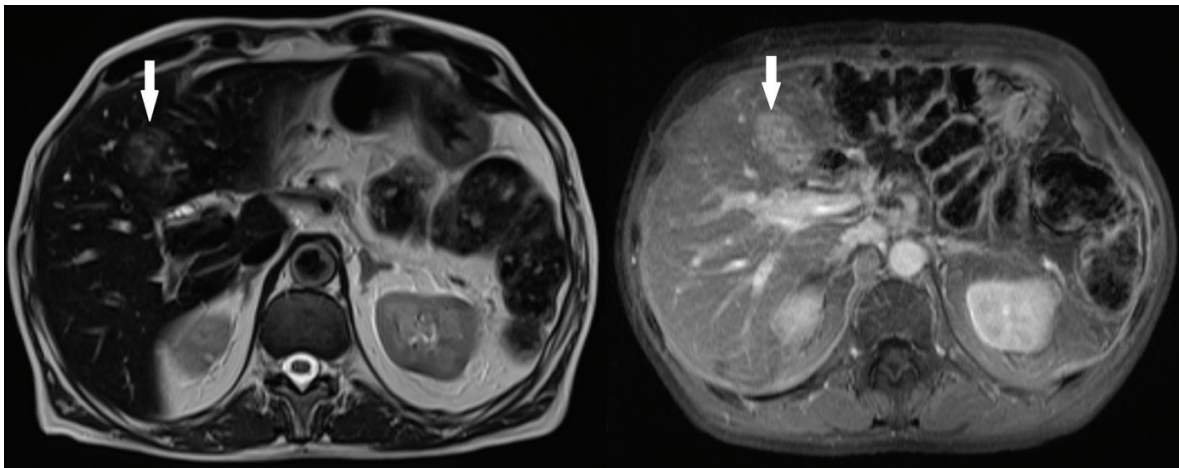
On the follow-up MRI obtained three months after surgery. Axial T2-weighted image (left) demonstrates that the cystic component of the lesion has transformed into a solid component (arrow). On axial post-contrast T1-weighted images (right), the lesion shows diffuse, homogeneous enhancement, confirming its solid nature (arrow)
